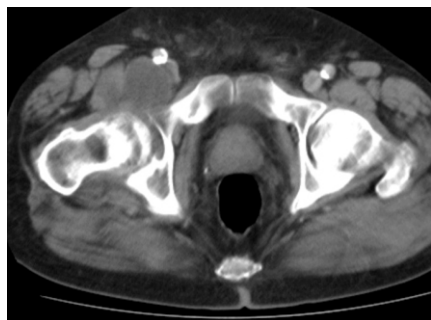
Axial CT Scan showing enlarged IB anterior to right hip.
